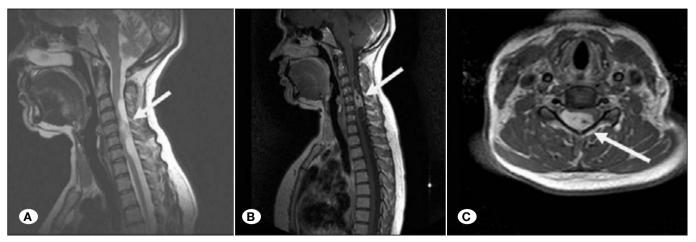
Preoperative Magnetic Resonance Imaging scans. A) T2 Sagittal image, B) T1 Sagittal image with contrast, C) T1 Axial image with contrast.
